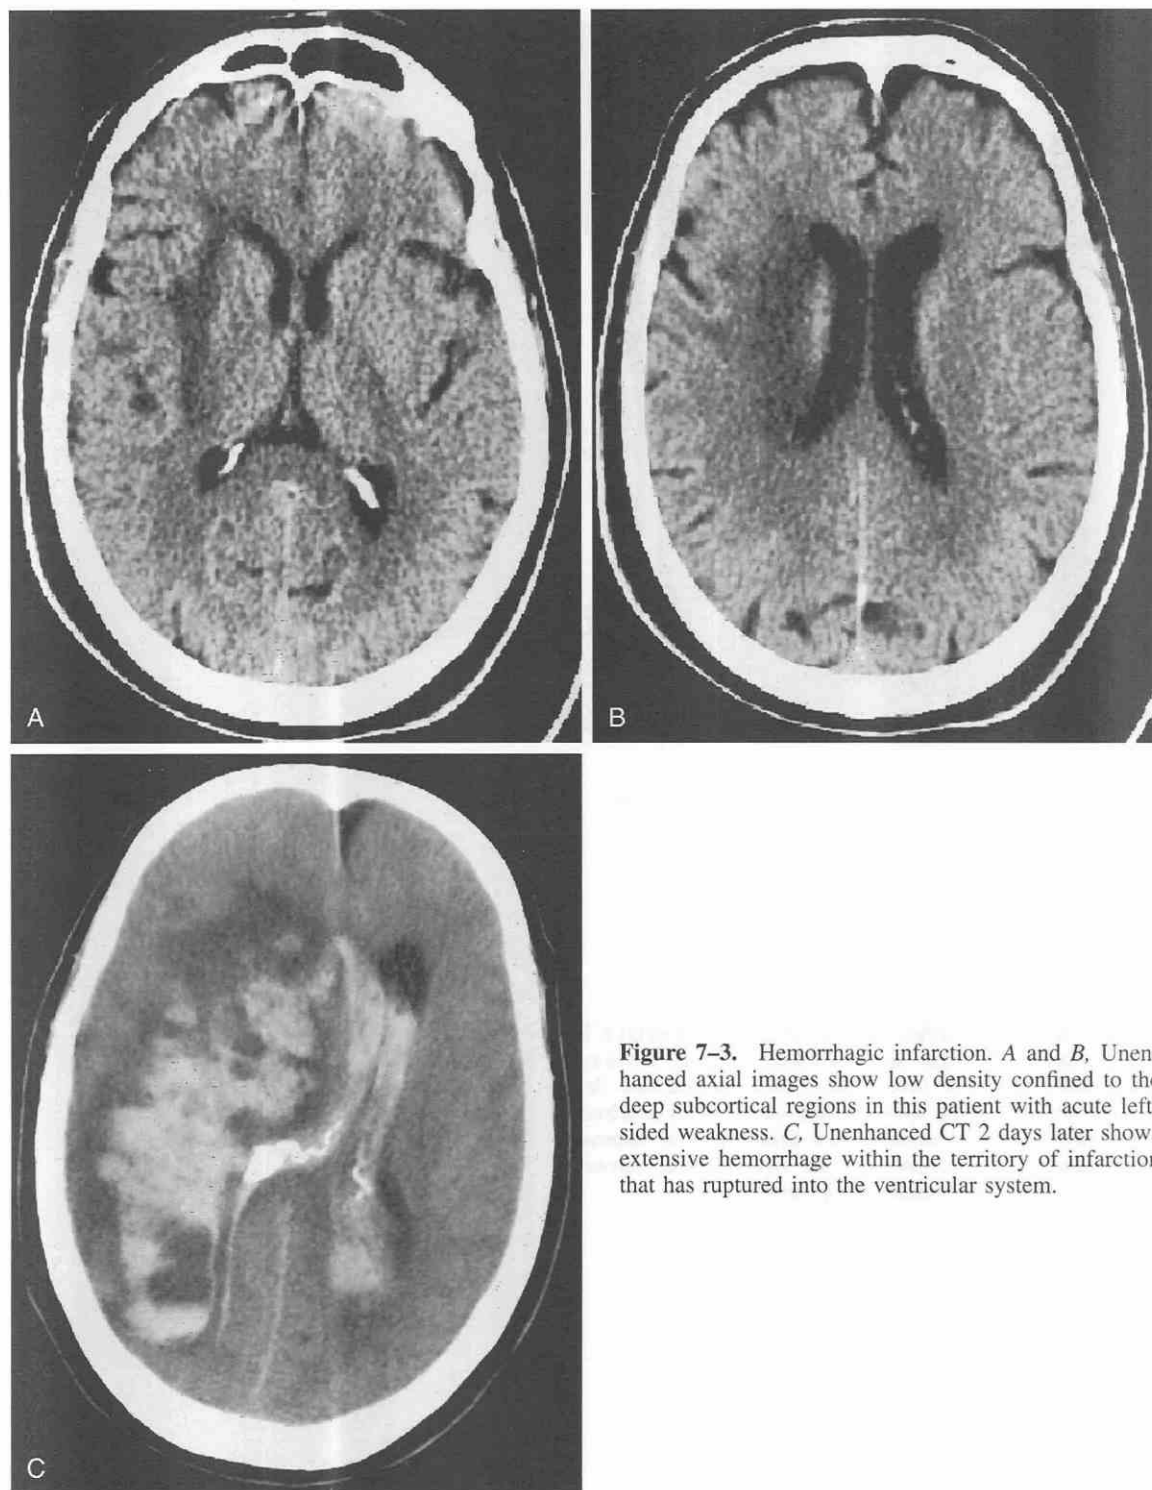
Hemorrhagic infarction. *A* and *B*, Unenhanced axial images show low density confined to the deep subcortical regions in this patient with acute left-sided weakness. *C*, Unenhanced CT 2 days later shows extensive hemorrhage within the territory of infarction that has ruptured into the ventricular system.
